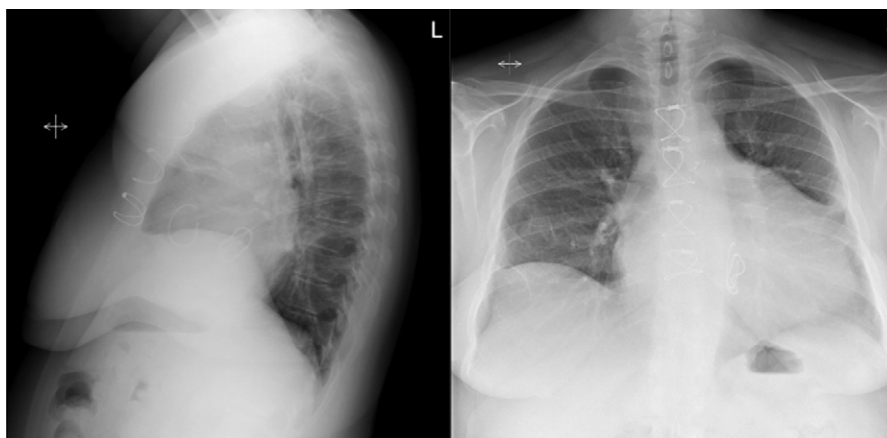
Lateral and pulmonary artery chest radiograph demonstrating double rigid annuloplasty rings in a 21-year transplanted heart. The radiograph demonstrates the complete rigid Geoform annuloplasty ring in a typical double-toroid configuration. The Carpentier classic partial rigid annuloplasty ring is seen as well.
